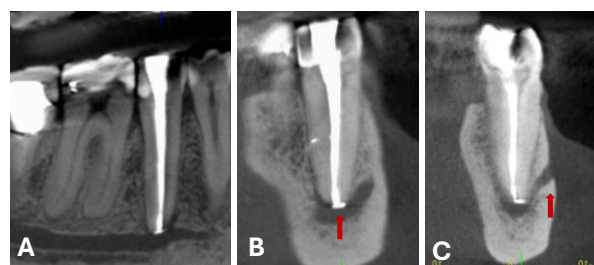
Post-treatment: A - CBCT in the sagittal section shows the proximity of the inferior alveolar nerve to the apical third of tooth 45; B - CBCT in the coronal section shows slight cement leakage; C - CBCT in the coronal section shows the mental foramen. (J. Morita Cone Beam Tomograph, Veraview X800). Source: images by the author, 2025.
